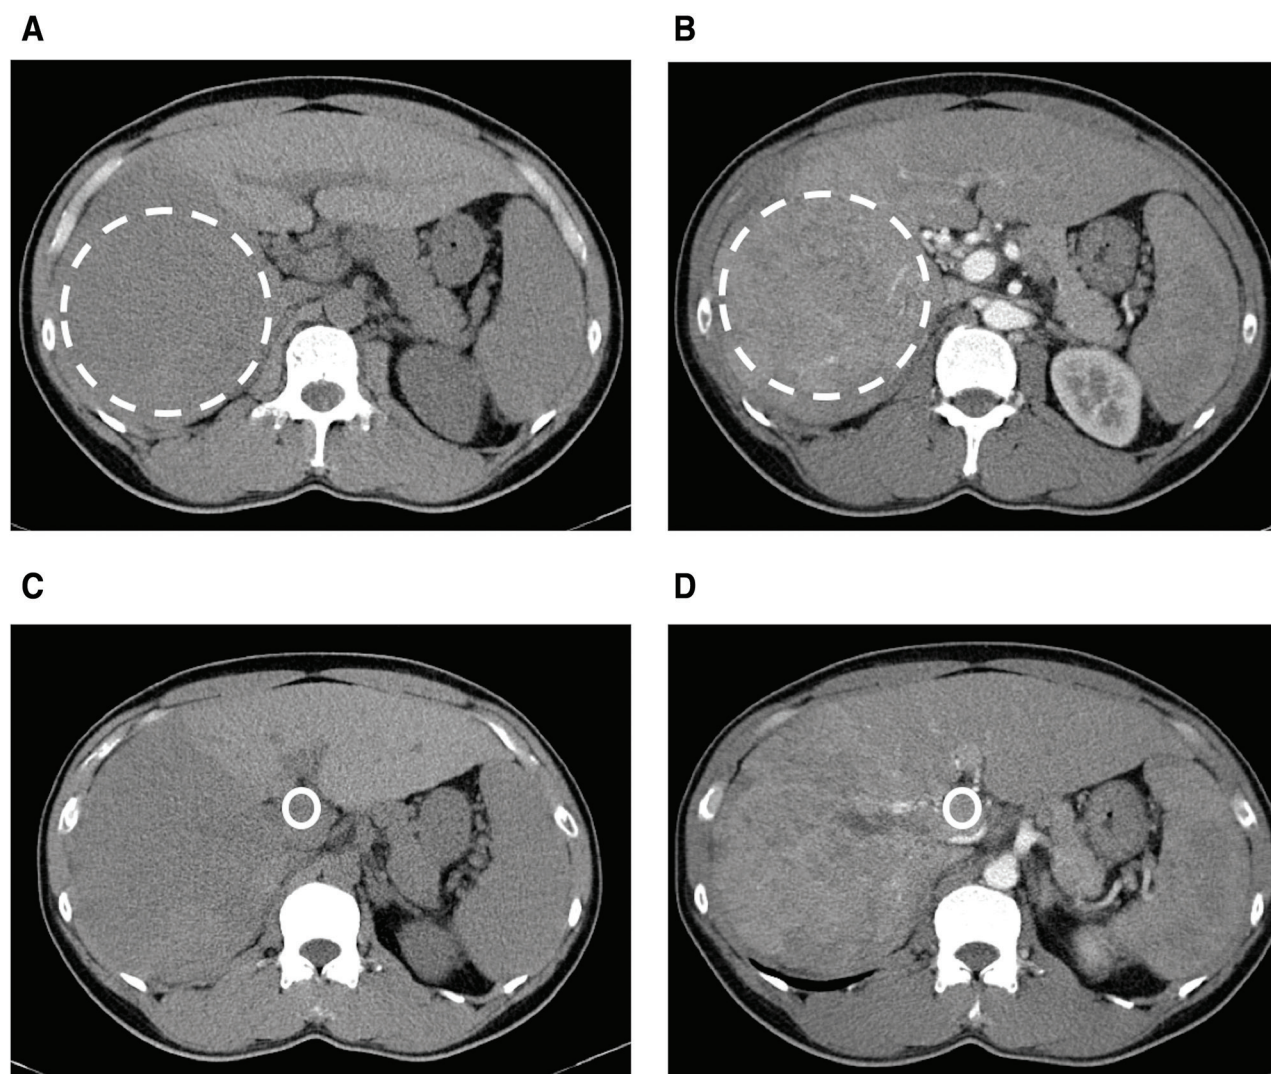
Infiltrative HCCs with portal vein tumor thrombosis (PVTT) and arterioportal shunting (APS) in a 45-year-old man with HBV-related liver cirrhosis. A and B, For HCCs in the right lobe, the ROI value of lesion attenuation on the unenhanced CT image (A) was 43 HU. On the arterial phase, the ROI value of lesion attenuation was 87 HU. Tumor arterial enhancement ratio (AER) was calculated as $(87-43)/43 = 1.02$. C and D, For PVTT in the right main portal vein, the ROI value of lesion attenuation on the unenhanced CT image (C) was 42 HU. On the arterial phase, the ROI value of lesion attenuation was 102 HU. AER_{PVTT} was calculated as $(102-42)/42 = 1.43$. HCC = hepatocellular carcinoma.
